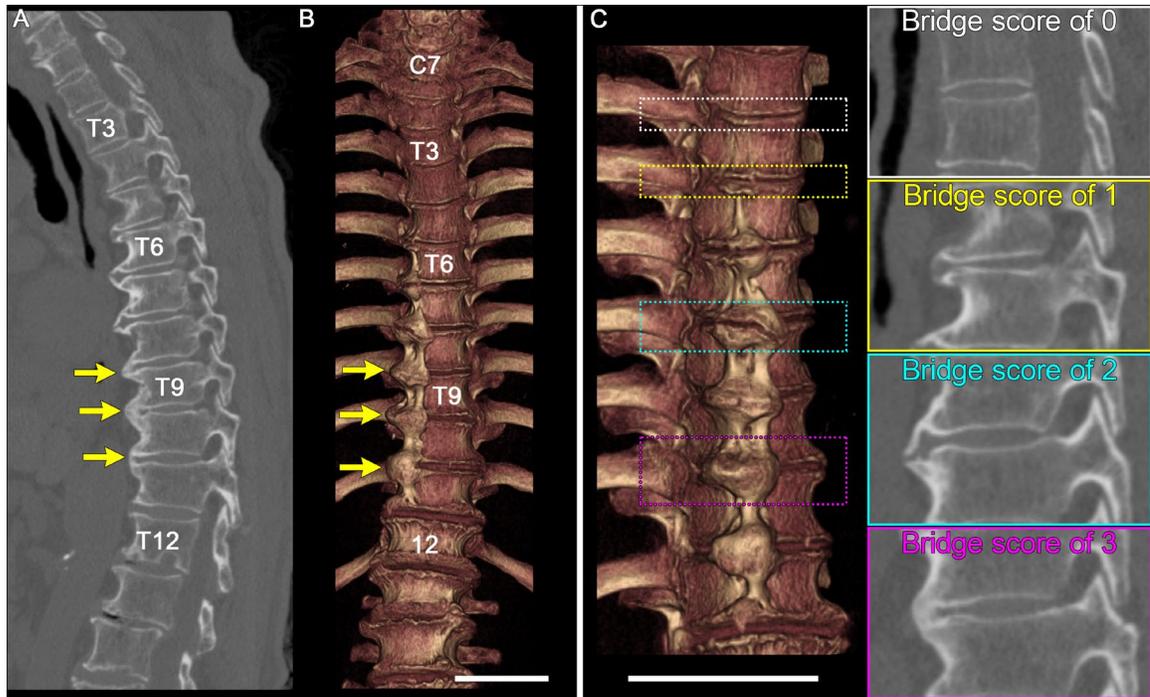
Representative computed tomography images and renderings of DISH
